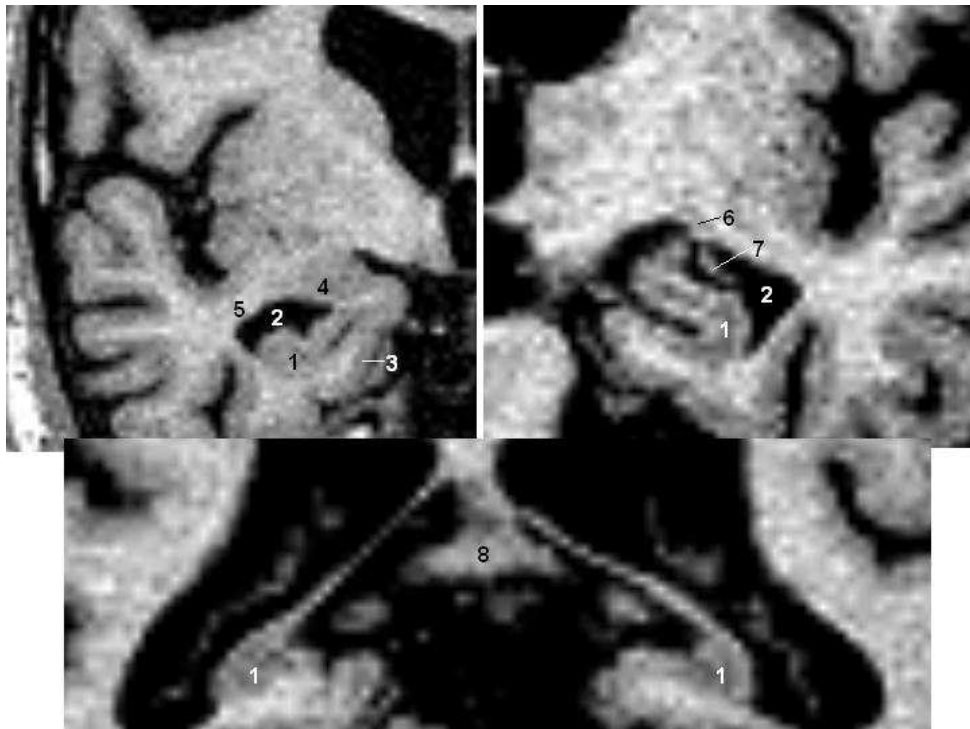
Coronal sections of the hippocampus on T1-weighted MRI. Left upper image most anterior, lower image most posterior slice.
